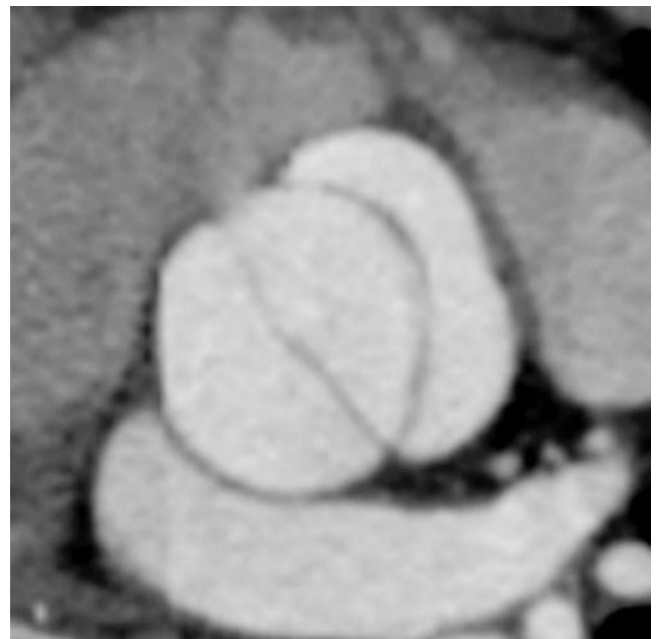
Demonstration of aortic root and aortic valve. Axial oblique multiplanar reformatted image from a systolic data set demonstrates an open bicuspid aortic valve. Note the precise definition of the aortic wall, free from the cardiac motion-related artifacts that are present in conventional thoracic CT scanning. Aortic root size measurements are highly accurate owing to a lack of motion artifacts and the high spatial resolution of the cardiac CT scanning (<0.5 mm).
